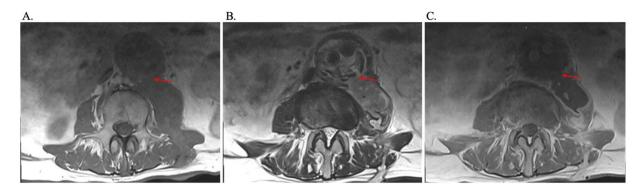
(A-C) MRI lumbosacral spine with and without contrast demonstrating a contiguous, rim enhancing fluid collection compatible with left psoas muscle abscess measuring  $2.4 \times 4.4 \times 9.2$  cm in transverse, anterior-posterior and longitudinal directions, respectively. Evidence of 2 fistulous tracts extending from fluid collection to the posterior skin surface. (A) represents the T1 spine without contrast, (B) represents the T2 spine without contrast and (C) represents the T1 spine with contrast.
